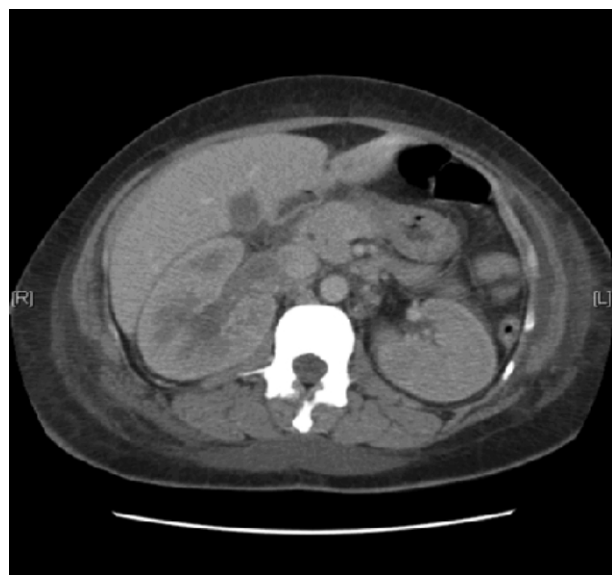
Enhanced CT can be obtained after injection with contrast medium, confirming a right renal vein thrombus.
